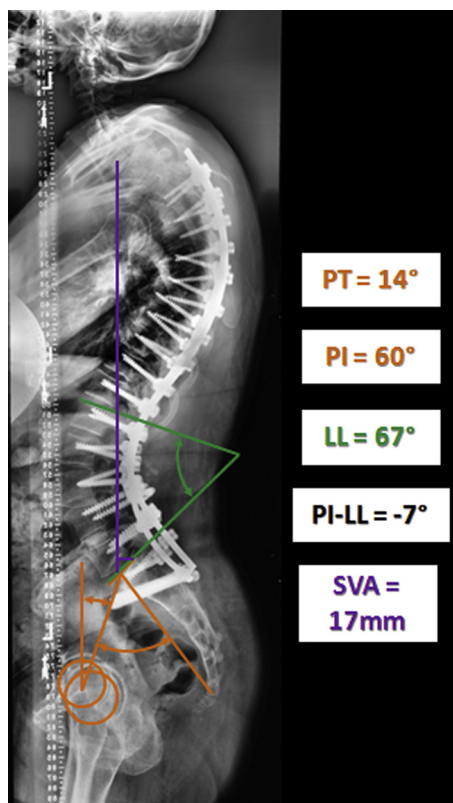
Preoperative and postoperative changes in radiographic parameters, including the cervical spine, after surgical treatment. LL, lumbar lordosis; PI, pelvic incidence; PT, pelvic tilt; SVA, sagittal vertical axis.
